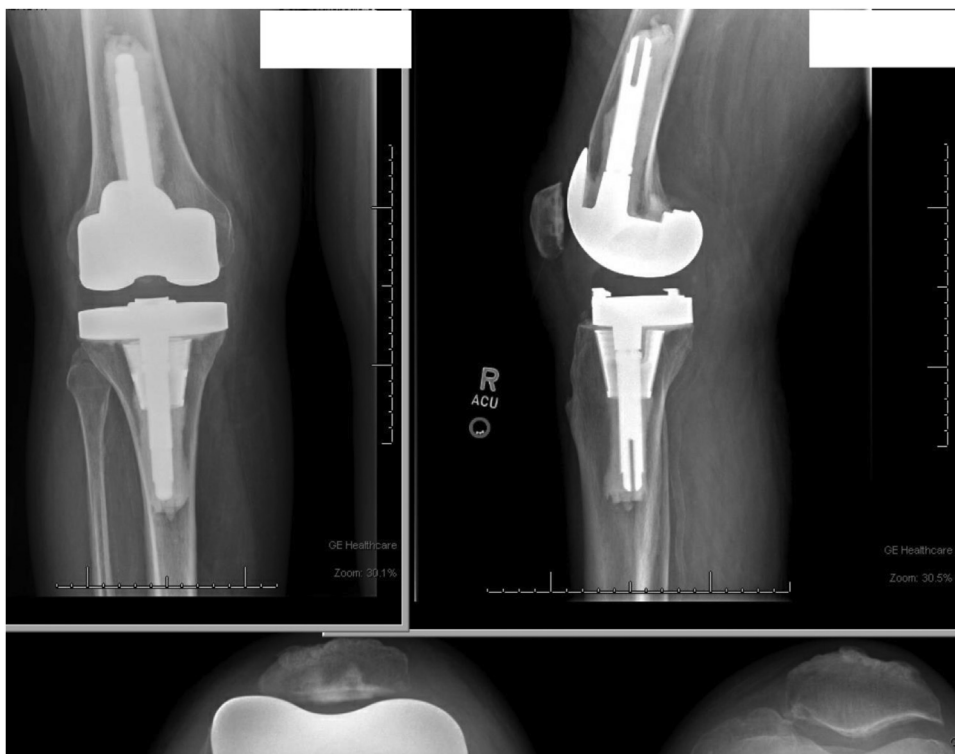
Postrevision x-rays demonstrating short, cemented stems and zone-2 tibial metaphysis cone with minimal effusion and a centrally tracking patella.
